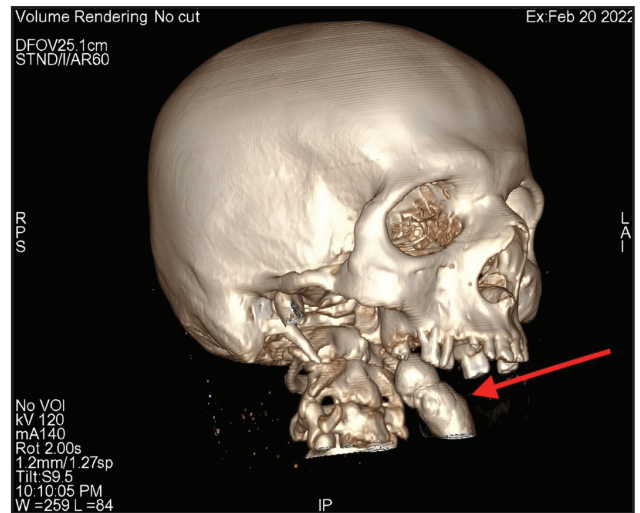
3D reconstructed CT images depicting the calcified lesion's heterogeneous nature and its proximity to surrounding anatomical structures.
